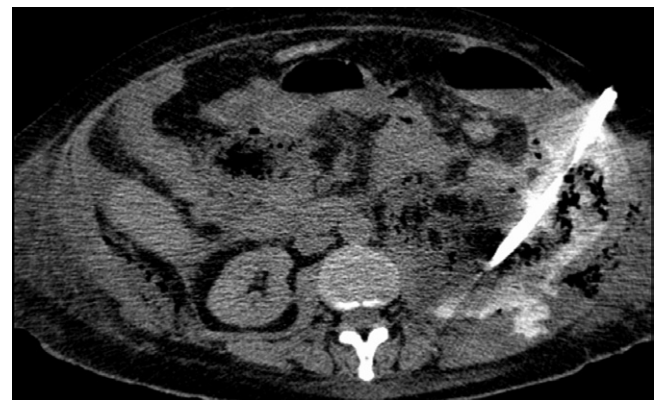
Extended pancreatic and retroperitoneal necrosis. Computed tomography-guided drainage of an extended retroperitoneal necrosis due to necrotizing pancreatitis.
